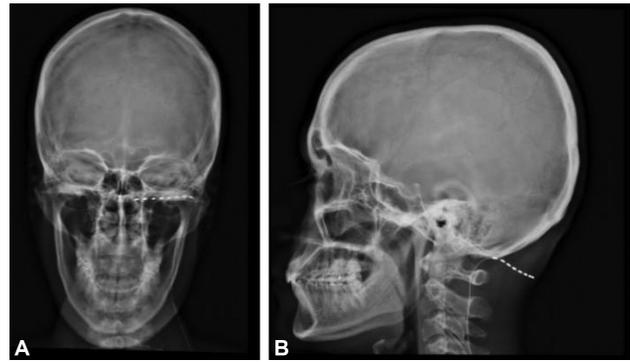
(A) Radiograph on coronal section. Radiograph on sagittal section.
